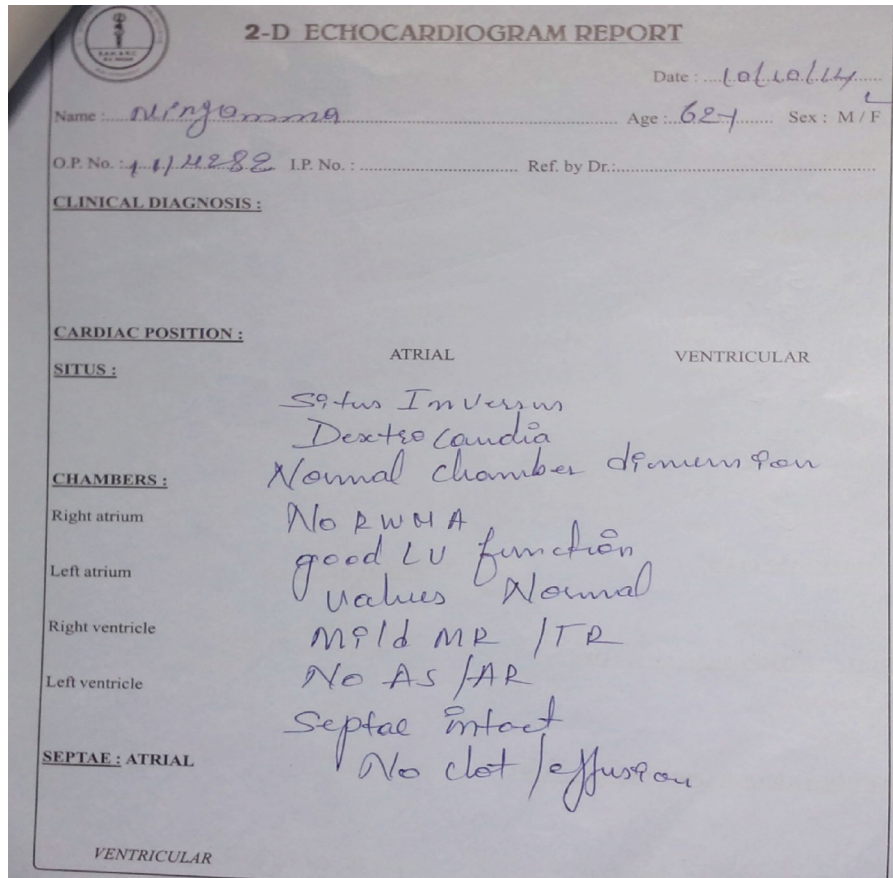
2D-Echocardiogram showing dextrocardia.
